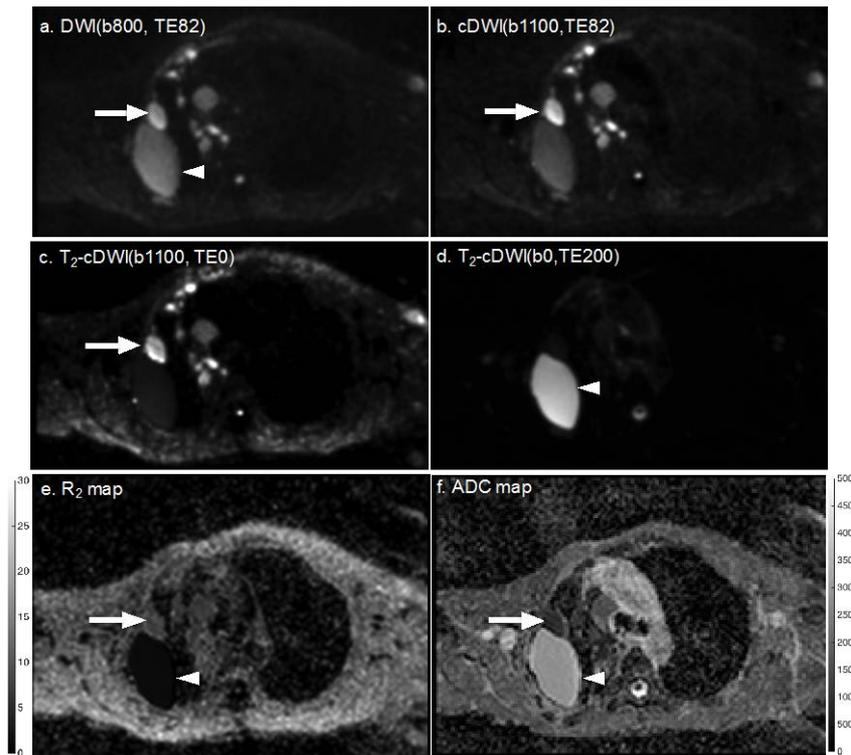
Axial images of a 62-year-old male with mesothelioma in the right lung for (a) acquired DWI (b800, TE82), (b) computed DWI (b 1100, TE82), (c) T_2 -cDWI (b1100, TE0), and (d) T_2 -cDWI (b, TE 200), (e) estimated R_2 map and (f) ADC map. b-value unit: 0 s/mm^2 , TE unit: ms.
